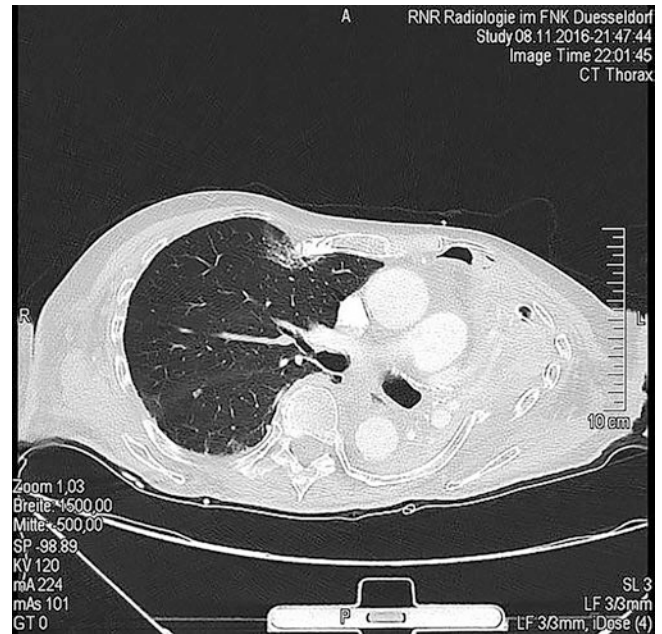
CT trauma scan; flail chest and complete atelectasis of left the upper lobe
